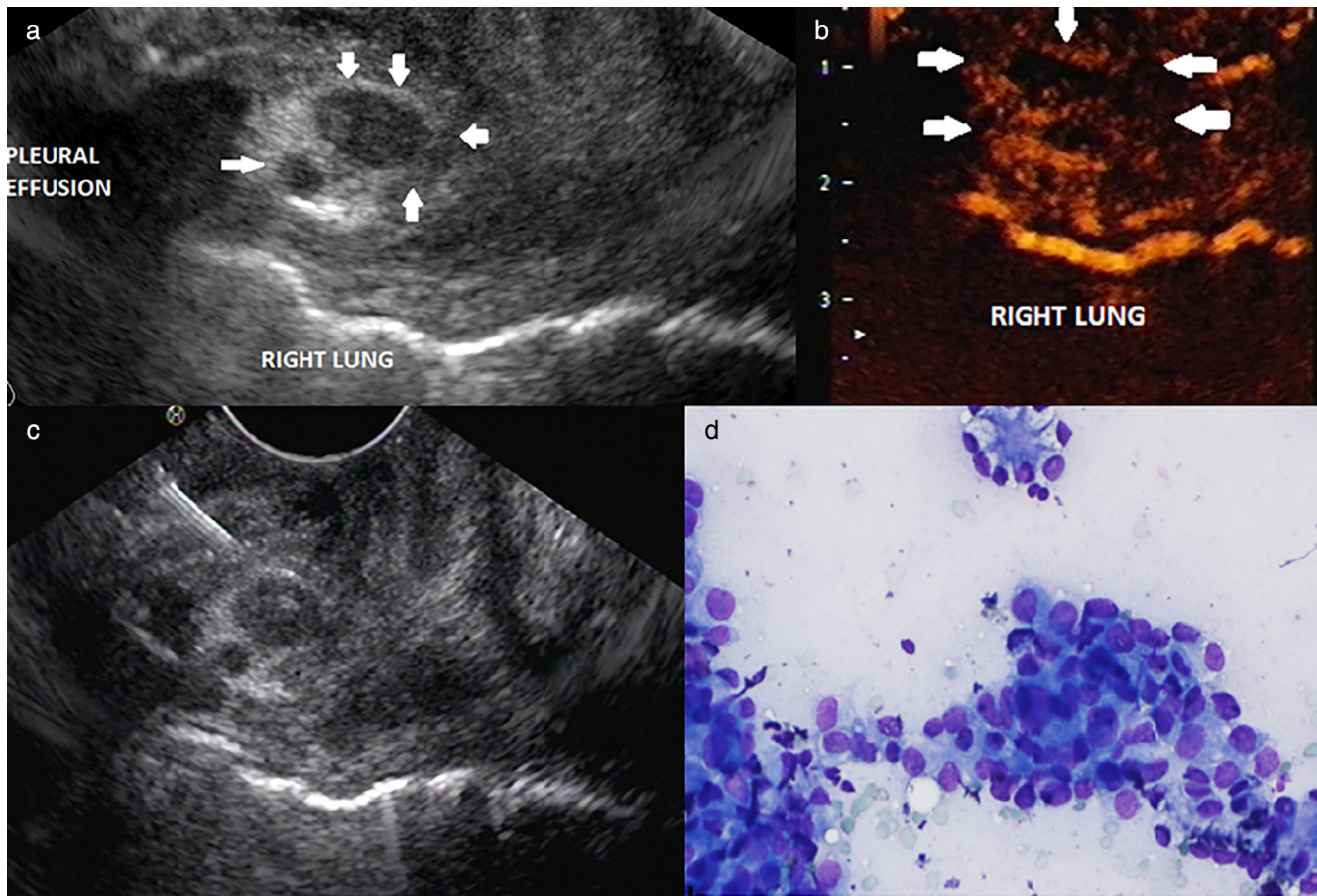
(a) Endoscopic ultrasound (EUS): Well-defined, rounded, and hypoechoic pleural deposits in the mediastinodiaphragmatic recess (arrows). (b) Contrast EUS: Pleural deposits showed peripheral enhancement (arrows). (c) EUS-guided fine-needle aspiration of pleural deposits being performed with a 22 G needle. (d) Cytological examination demonstrated the presence of tumor cells with nuclear pleomorphism, suggestive of metastatic adenocarcinoma (May Grunwald Giemsa, 20x).
